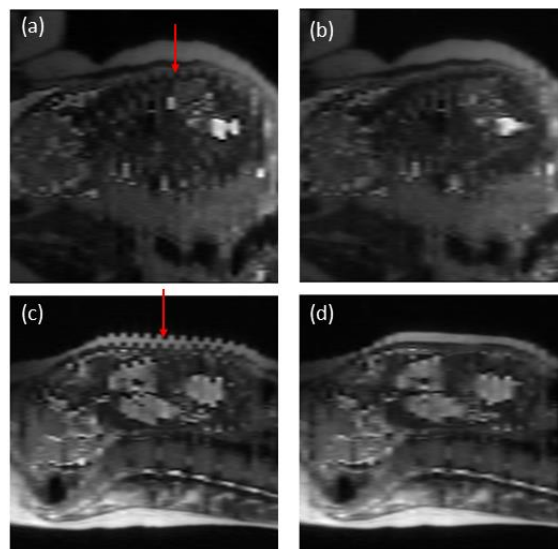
Sagittal cross section of MR image volumes pre- and post-registration for two patient cases with severe interleaved slice misalignment. A) and b) are pre- and post-registration results, respectively, for case 1. C) and d) are pre- and post-registration results, respectively, for case 2.
